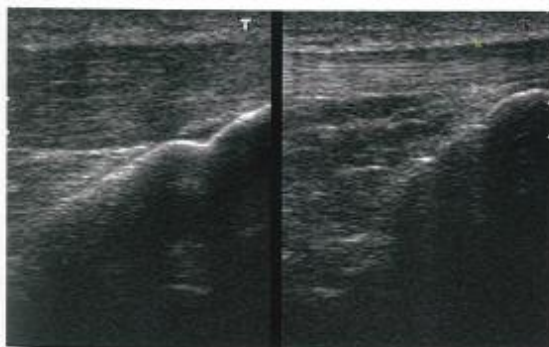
Ultrasound image of a reactive tendon (on left) showing diffuse thickening (note intact collagen fascicles) compared with normal tendon (right).
